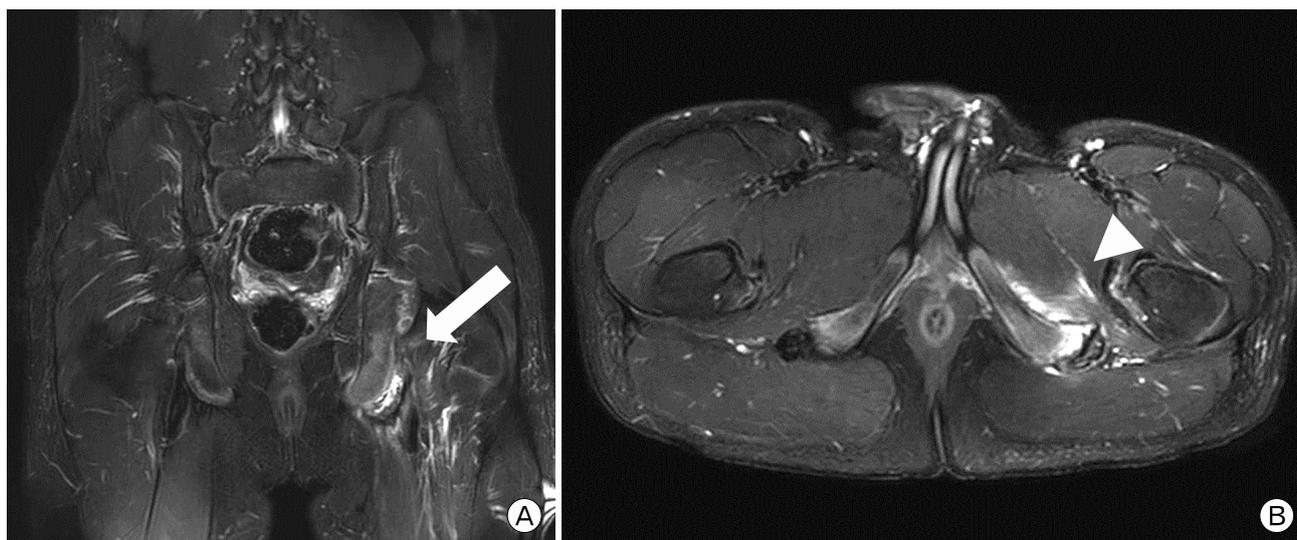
(A) Coronal T2-weighted magnetic resonance image showing displacement of left ischial tuberosity with partial tear of hamstring tendon (arrow). (B) Axial T2-weighted magnetic resonance image showing apophyseal avulsion of ischial tuberosity and acute strain in adductor magnus muscle (arrowhead).
